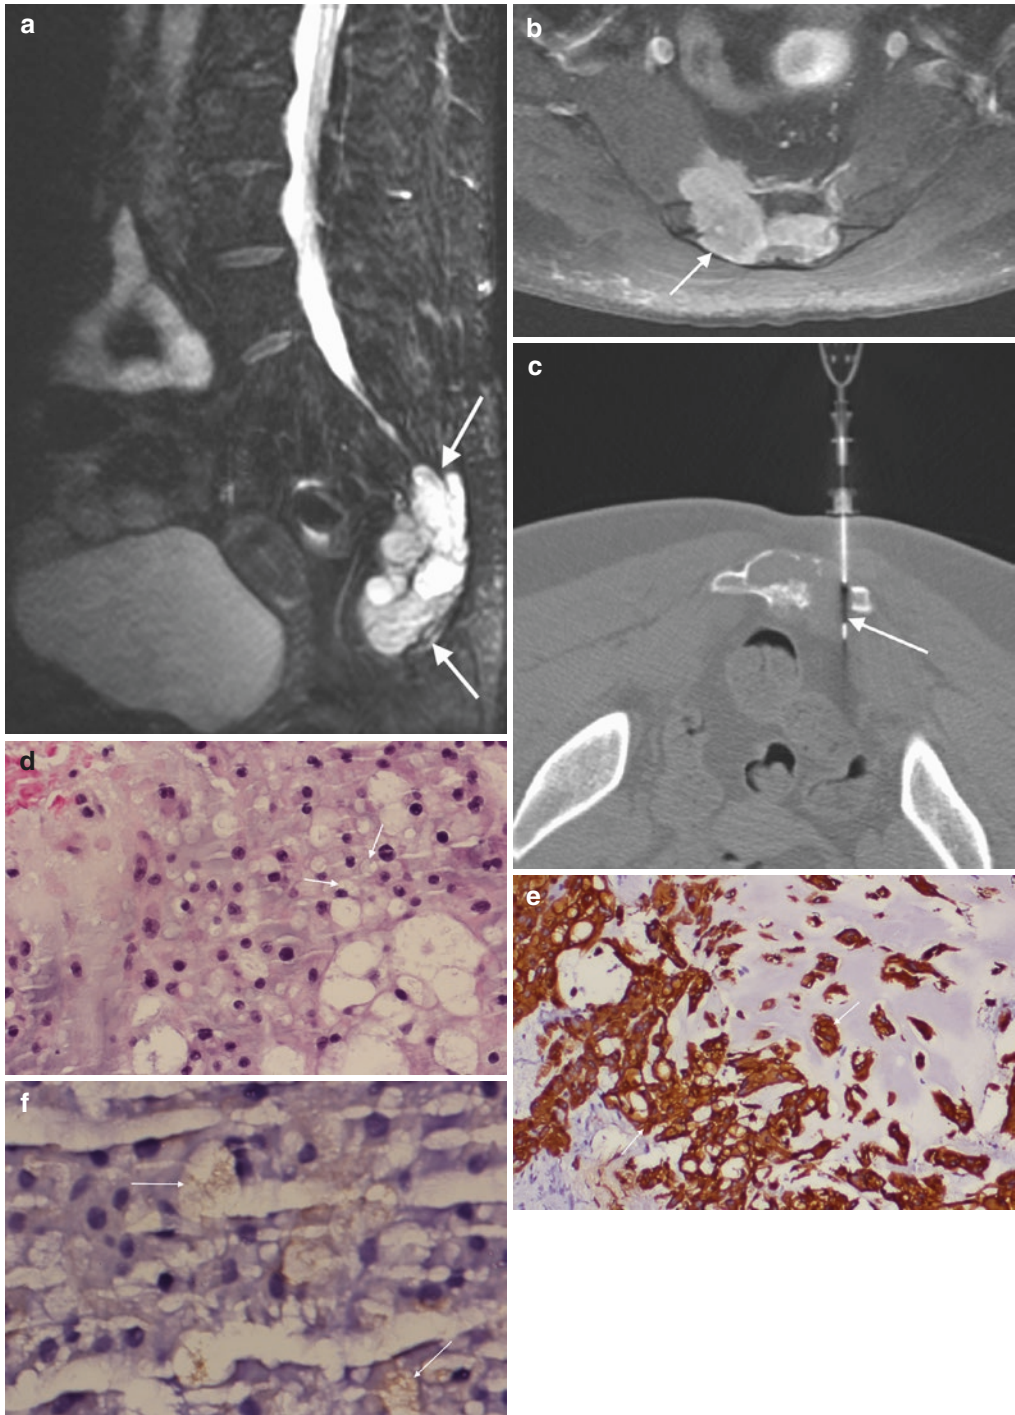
A 57-year-old female with 3 year history of pain radiating to the lower extremities. Fat-suppressed T2-weighted sagittal image (a) shows large lobulated hyperintense sacral mass (arrows). Fat-suppressed contrast-enhanced T1-weighted axial image (b) shows an enhancing sacral mass (arrow) at the S5 level. Axial CT image (c) during biopsy procedure with coaxial technique shows soft
